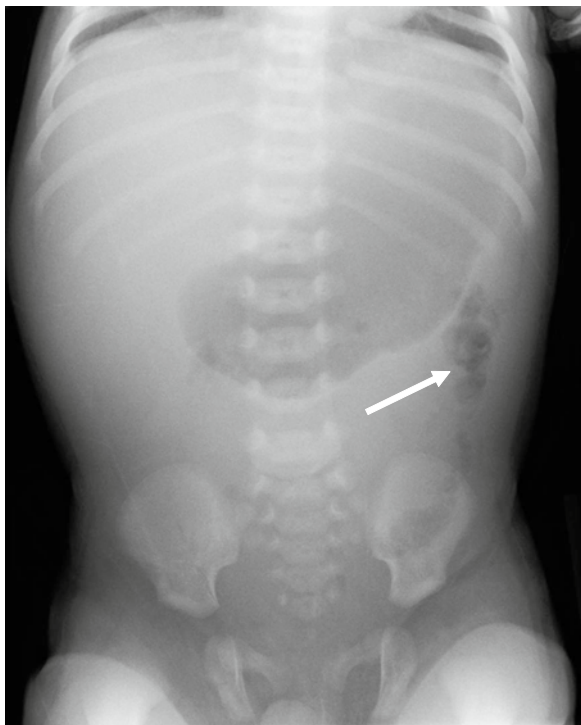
Abdominal radiograph demonstrating proximal intestinal obstruction with distended stomach and distal intestinal gas (*arrow*). This mandates evaluation for malrotation.
